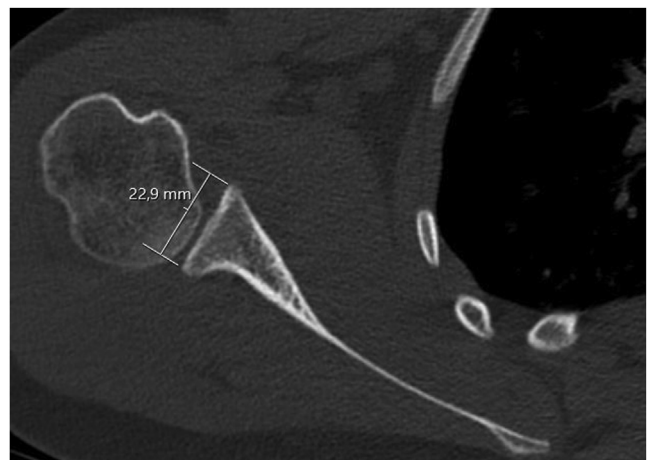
Axial view on the computed tomography scan in a patient lying on his back of a right glenohumeral joint measuring a glenoid diameter of 22.9 mm.
